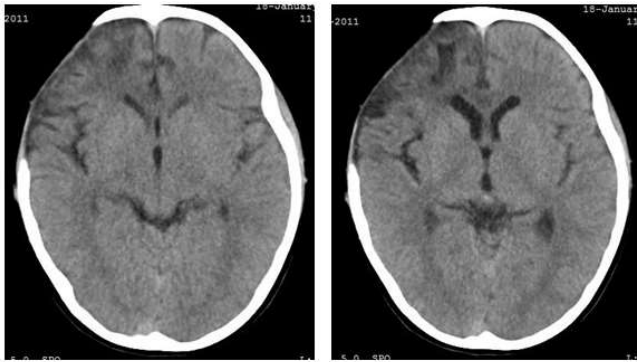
Cranial CT scan. Control
